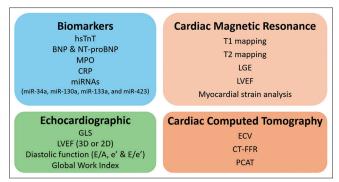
Multimodal approaches for the detection and diagnosis of cancer therapy-related cardiac dysfunction (CTRCD). Various diagnostic tools, including biomarkers, echocardiography, cardiac computed tomography and cardiac magnetic resonance imaging, are crucial for the early detection of CTRCD to prevent long-term cardiovascular damage and optimize cancer treatment. 2D: Two-dimensional; 3D: Three-dimensional; BNP: Brain natriuretic peptide; CMR: Cardiac magnetic resonance; CRP: C-reactive protein; CT-FFR: Computed tomography-derived fractional flow reserve; CTRCD: Cancer therapy-related cardiac dysfunction; e': Early diastolic mitral annular velocity; E/A: Early to late ventricular filling velocity ratio; ECV: Extracellular volume; E/e': Ratio of early mitral inflow velocity to early diastolic mitral annular velocity; GLS: Global longitudinal strain; hsTnT: High-sensitivity troponin T; LGE: Late gadolinium enhancement; LVEF: Left ventricular ejection fraction; miRNA: MicroRNA; MPO: Myeloperoxidase; NT-proBNP: N-terminal pro-brain natriuretic peptide; PCAT: Pericoronary adipose tissue; T1 mapping: Longitudinal relaxation time mapping; T2 mapping: Transverse relaxation time mapping
